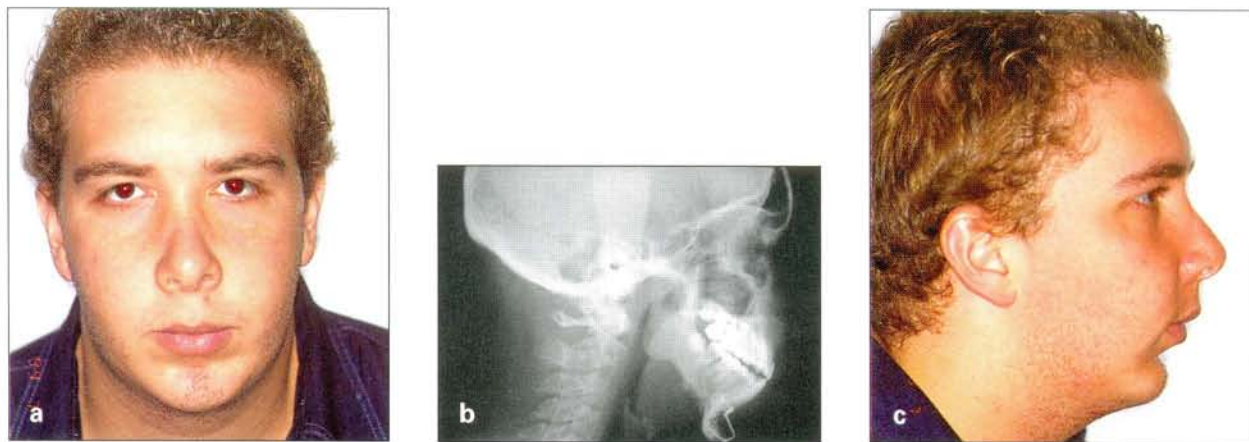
July 1, 1999 (age 21 years, 3 months): (a) Frontal view. (b) Radiograph. (c) Profile view.
